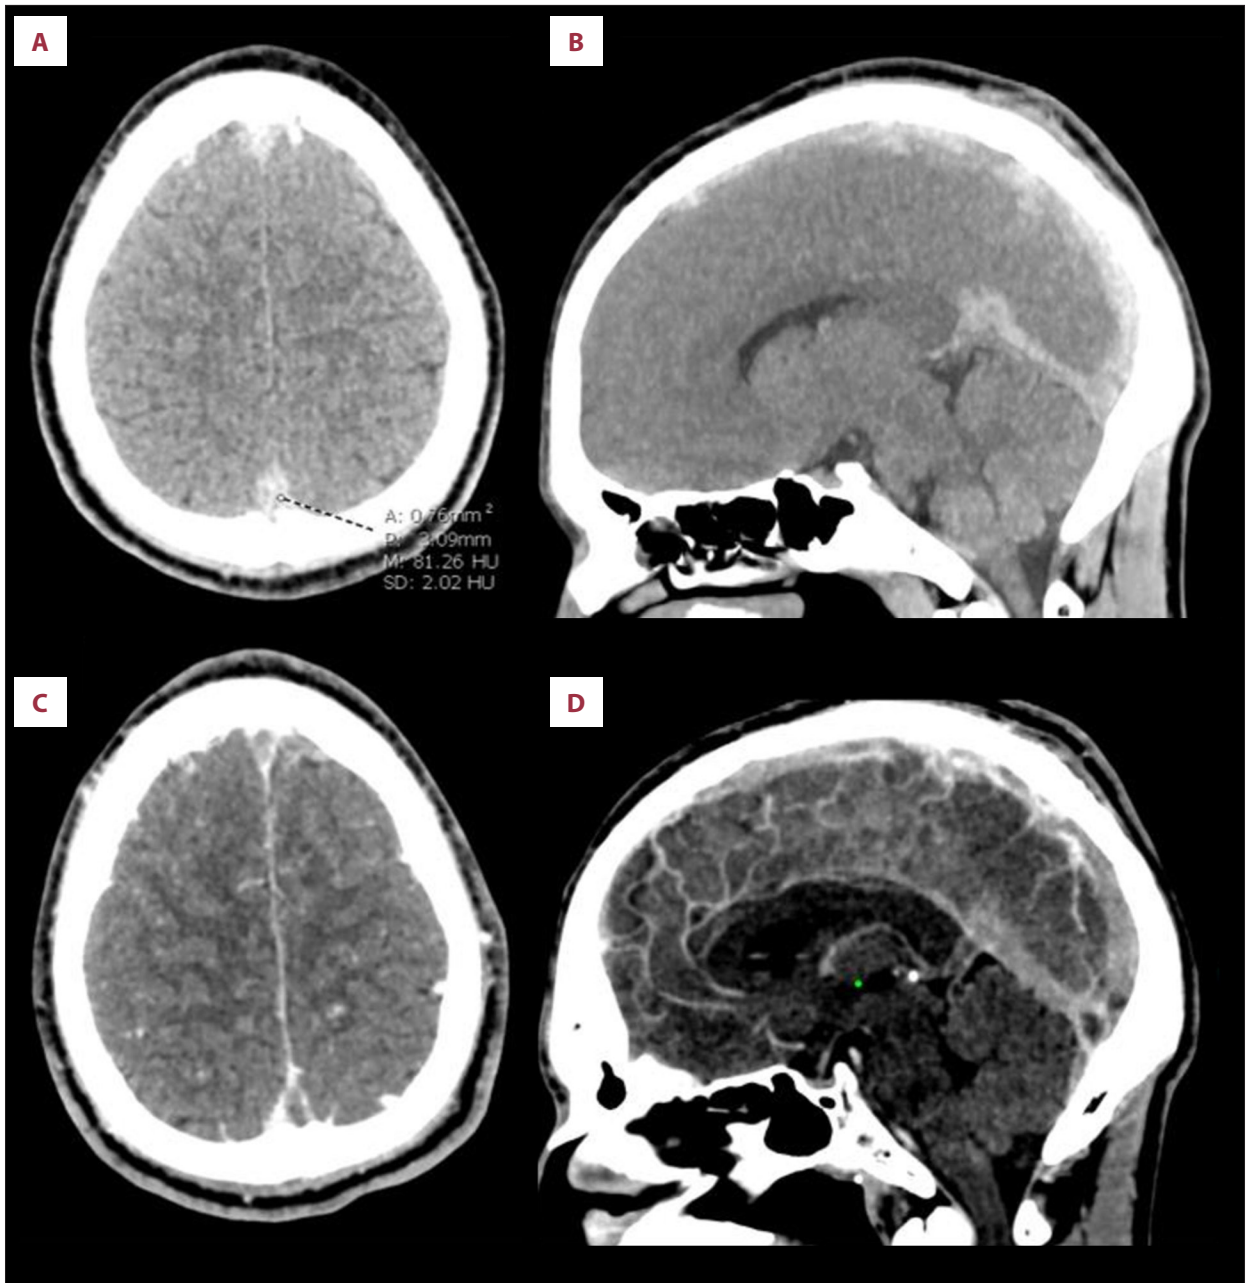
Unenhanced CT brain and contrast-enhanced CT venography. (A) Axial and (B) midline MIP sagittal images from unenhanced CT show hyperdense superior sagittal sinus (CT density of about 80 Hounsfield units), straight sinus and bilateral frontal parasagittal cortical veins concerning for thrombosis. (C) Axial and (D) midline sagittal CT venography images confirm filling defects in the cerebral dural venous sinuses and cortical veins indicative of thrombosis. Thrombosis extended into the transverse and sigmoid sinuses and left internal jugular vein (not shown).
